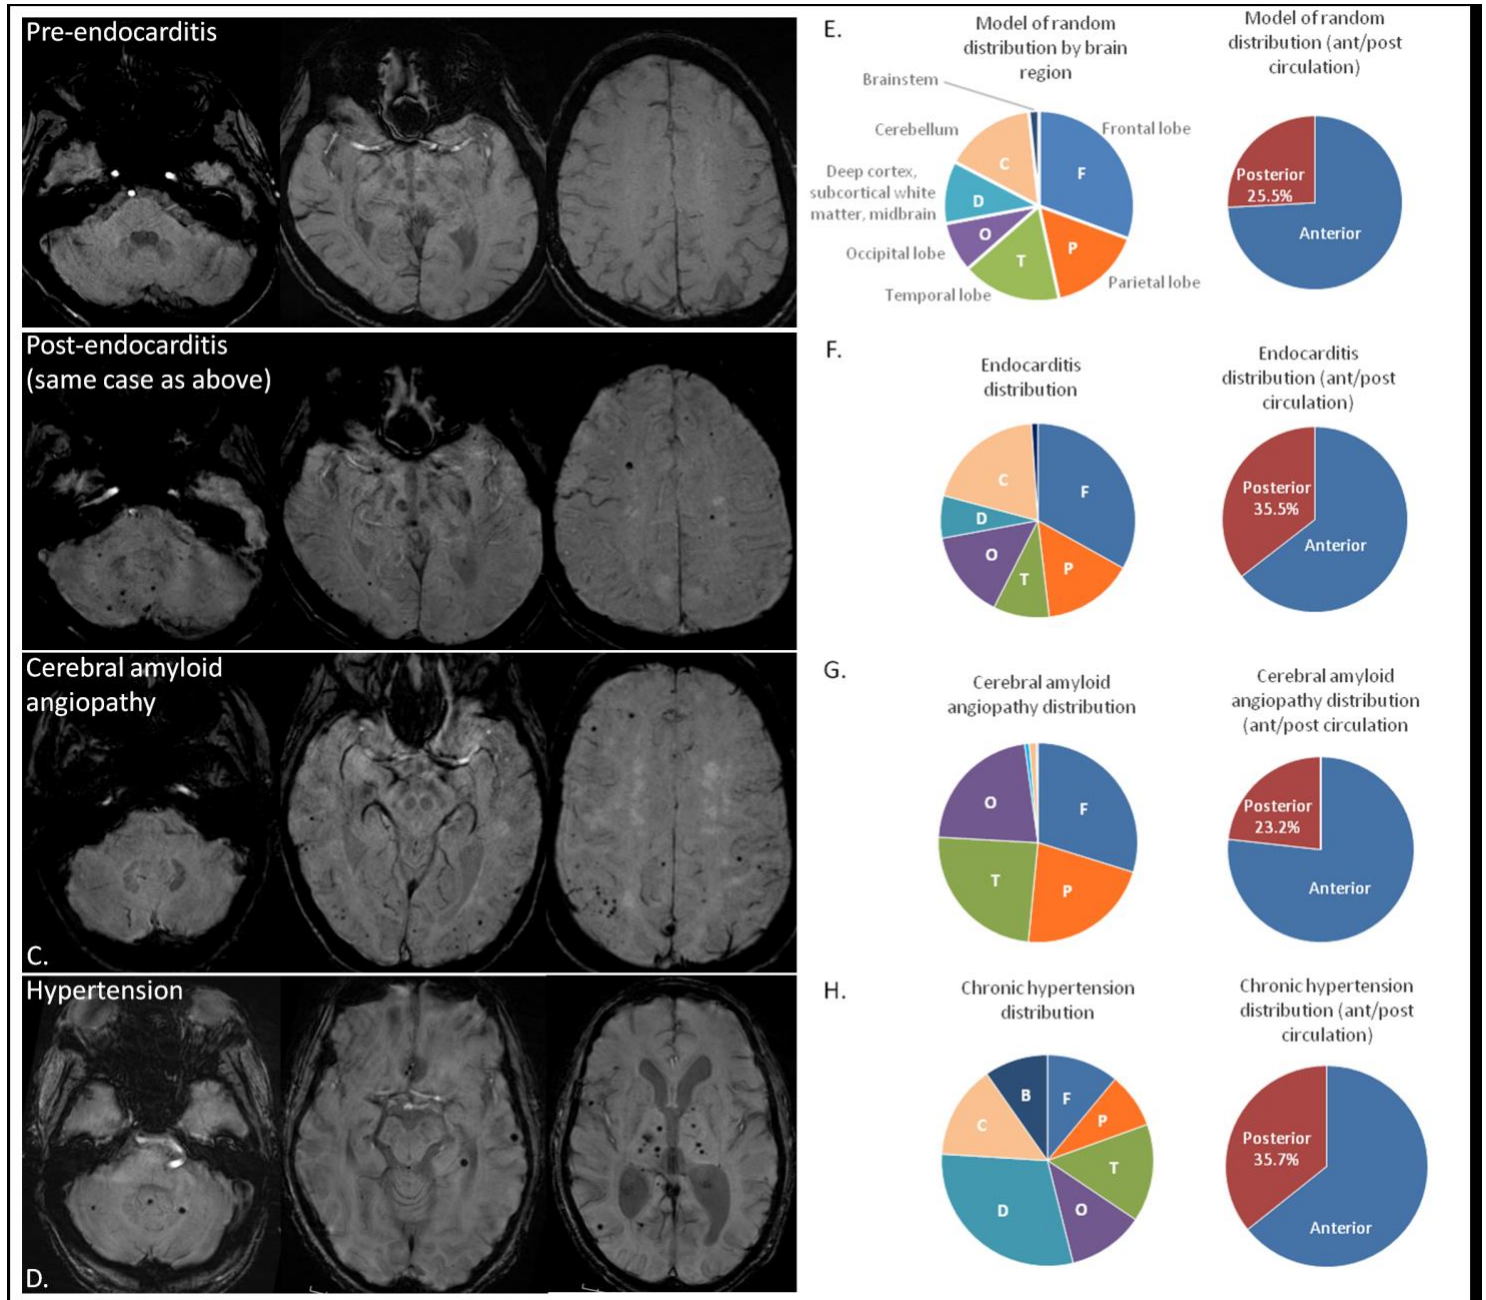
A. MRI from a patient prior to an episode of infectious endocarditis does not demonstrate microhemorrhages. B. Matched images from the same patient after the onset of infectious endocarditis demonstrates multiple microhemorrhages and an area of cortical superficial siderosis in the right frontal lobe. C. Typical MRI from a patient with cerebral amyloid angiopathy demonstrates the cortical/lobar pattern of microhemorrhages which rarely involves the cerebellum or deeper structures. D. Typical MRI from a patient with severe chronic hypertension demonstrates widely distributed microhemorrhages with a preference for the basal ganglia and frequently involving the cerebellum. E. A model of a predicted random distribution of microhemorrhages in the brain is shown in the first row for comparison. F. The distribution of microhemorrhages in infective endocarditis involves essentially every brain region but has a significant preference for the posterior circulation, particularly the cerebellum when compared to a random distribution. G. The distribution of microhemorrhages in cerebral amyloid angiopathy is shown to spare the basal ganglia and cerebellum with preferential involvement of cortical areas. H. The distribution of microhemorrhages in patients with severe chronic hypertension preferentially involves in the basal ganglia, but does not spare cortical areas or the cerebellum.
